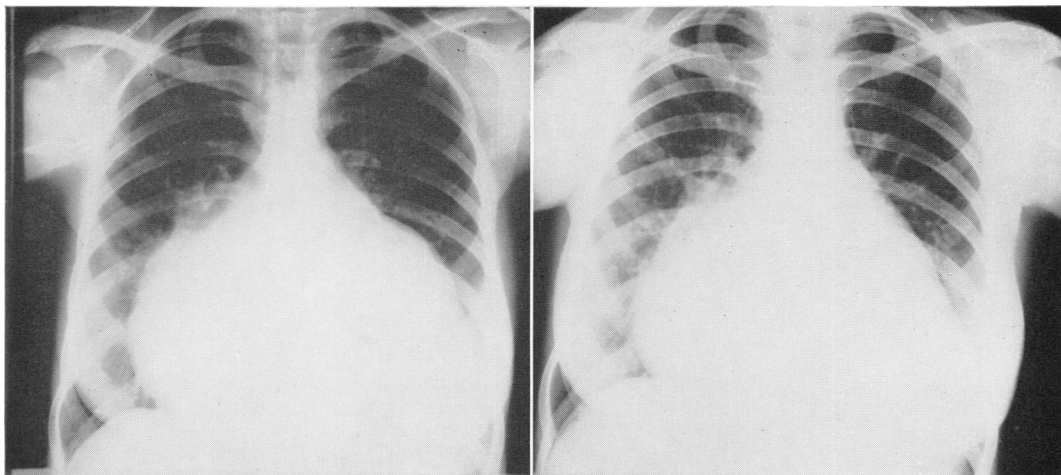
X-ray before and 6 months after mitral and tricuspid annuloplasty. Despite excellent repair and marked improvement, heart is still enlarged.
